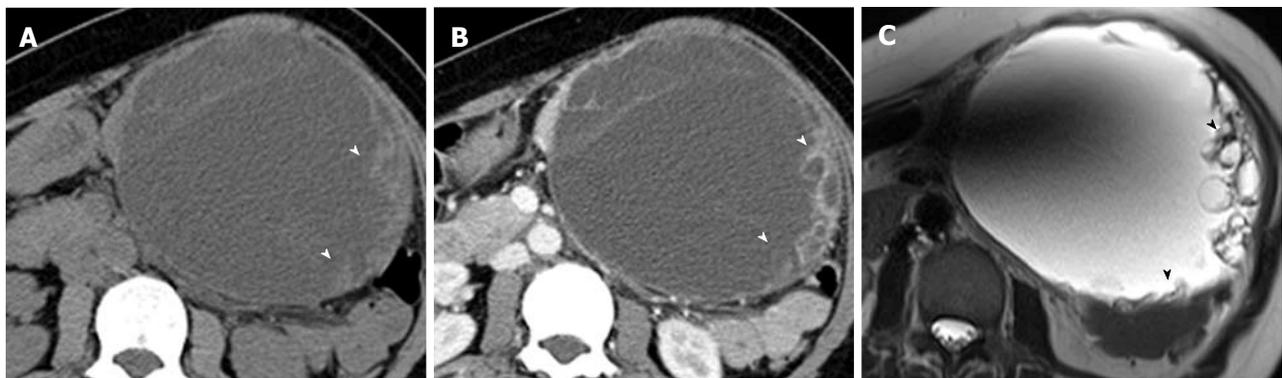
Mucinous cystadenocarcinoma of the pancreas in a 44-year-old woman. A, B: Non-enhanced (A) and contrast-enhanced (B) CT images show a well-circumscribed multi-septated cystic mass with enhancing soft tissue components (arrowheads) in the tail of the pancreas; C: T2-weighted MR image shows a large multilocular cystic mass with high signal intensity and peripheral soft tissue components with low signal intensity (arrowheads) in the pancreatic tail. CT: Computed tomography; MR: Magnetic resonance.
